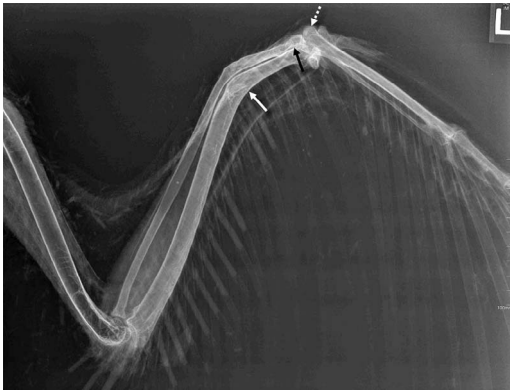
Ventral-dorsal view radiograph taken at necropsy of the left wing of a 13 mo old Whooping Crane (*Grus americana*) from the Louisiana, USA nonmigratory population with a wing abnormality. A moderate (about 30°) caudal angulation was present associated with the distal diaphysis of the radius and ulna (white arrow), with a marked reduction in the radioulnar gap and mild irregular shape of both cortices cranially at the location of the angulation. A fracture line was not visible. The distal epiphysis of the radius was narrow and the joint space between the radius and radial carpal bone was ill-defined (black arrow). The major metacarpal bone was moderately cranially displaced (dotted white arrow). Osseous findings were consistent with an axial malunion of the left radius and ulna with moderate left carpal subluxation.
